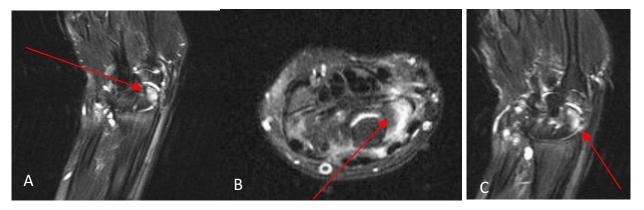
MRI Sections showing effusion at the intercarpal joint (A) and bone edema (B, C) in the distal scaphoid of the right wrist shown with arrows.
